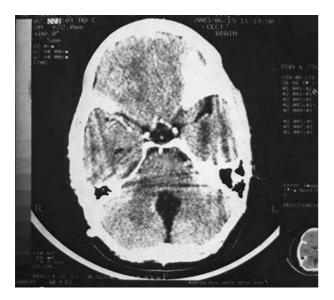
Postoperative follow-up CT scan showing no sign of any residual disease or tumor at a new site.
